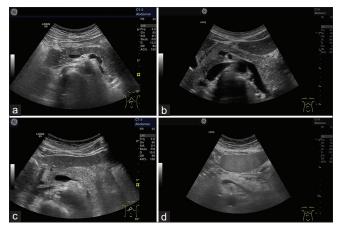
Graduation of pancreatic echogenicity in comparison to healthy liver on ultrasound according to Marks *et al.* and Worthen *et al.*: equal (a), slightly greater (b), greater than liver (c), and the region of the pancreas is sufficiently echogenic so that the boundary between pancreatic tissue and retroperitoneal fat could not be determined (d)
